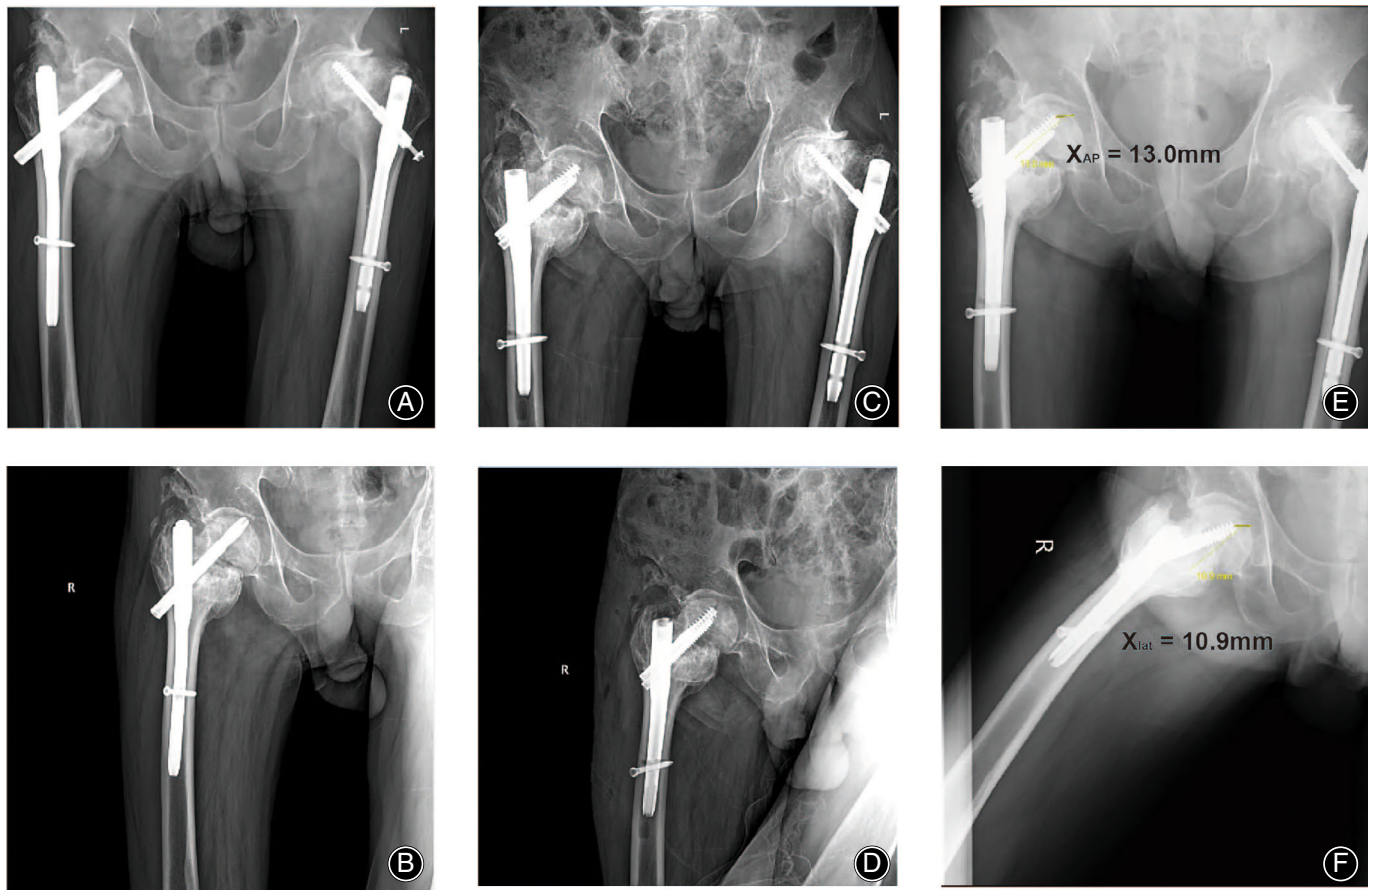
Radiographs before and after the revision operation. (A, B): preoperative lateral and anteroposterior X-ray of the right hip joint shows cut-through of the helical blade of the PFNA-II; (C, D): lateral and anteroposterior X-ray after revision with INTERTAN; (E, F): the tip-apex distance (TAD) in AP (13.0 mm) and lateral (10.9 mm) view after the first operation, and final TAD is addition of both the values (23.9 mm)
